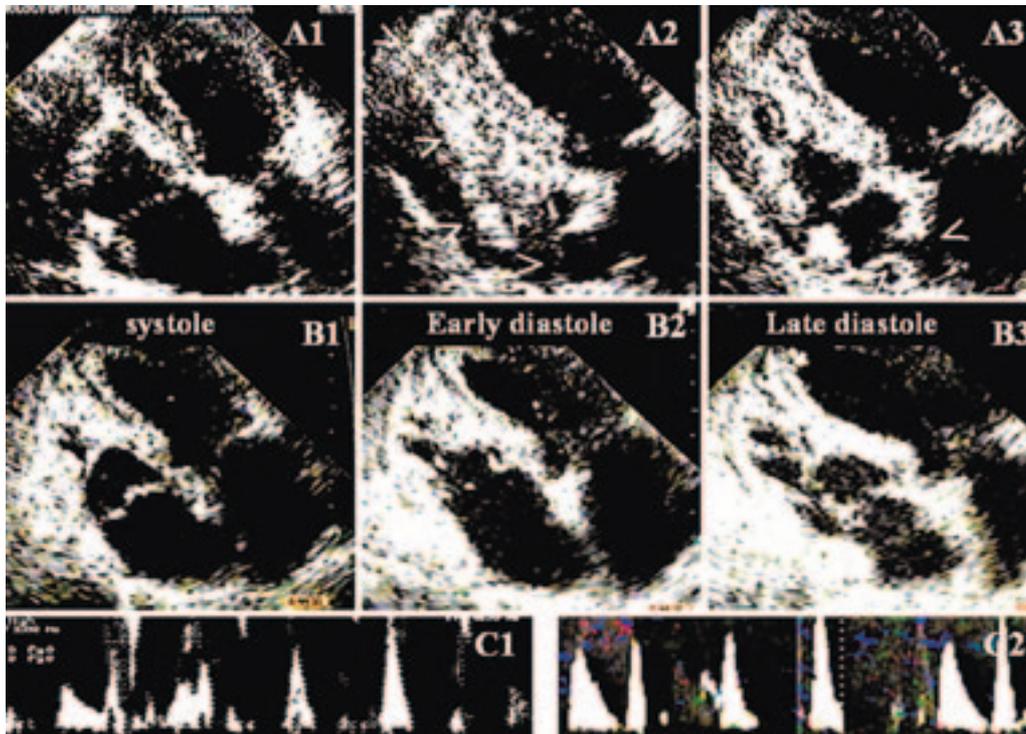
Transthoracic echocardiograms, 4-chamber view, in systole, early and late diastole. A1-3: Pericardial effusion after tube placement. Note the diastolic collapse of the right chambers in early diastole and of the right atrium in late diastole. (white arrows). B1-3: Same views 6-8 hours later. Disappearance of pericardial fluid. There are no signs of cardiac tamponade. C1: Exaggerated respiratory variation of mitral inflow during the 1st echo study. C2: Normal variation of mitral inflow during follow up.
